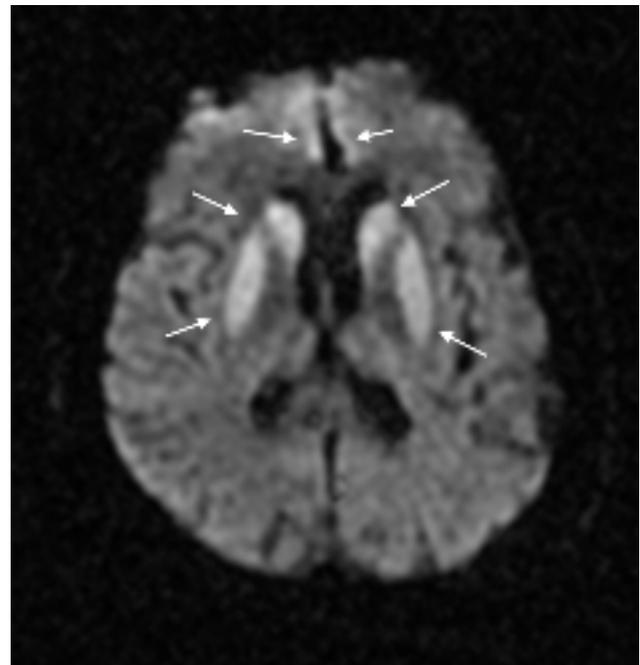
MRI of the brain with diffusion-weighted and fluid attenuated inversion recovery images shows increased signal intensity predominantly in the bilateral caudate nucleus, putamen, posteromedial thalamus, and frontal cortex.
